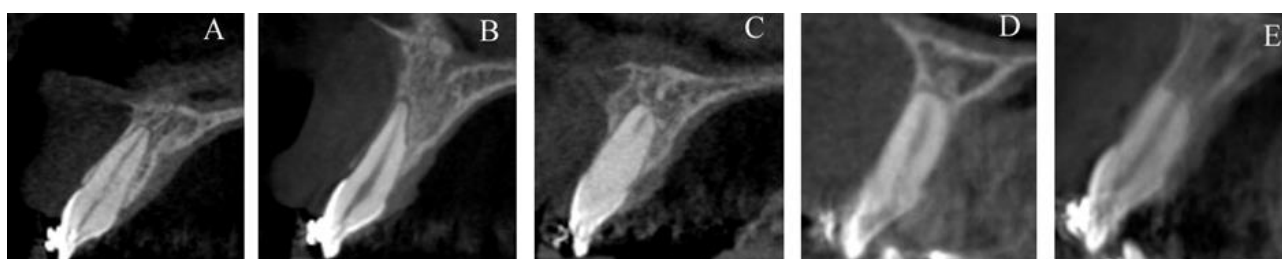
Index for evaluation of root resorption on the CBCT: A, 0, no resorption; B, 1, mild resorption; C, 2, moderate resorption; D, 3, severe resorption; E, 4, Extreme resorption.
